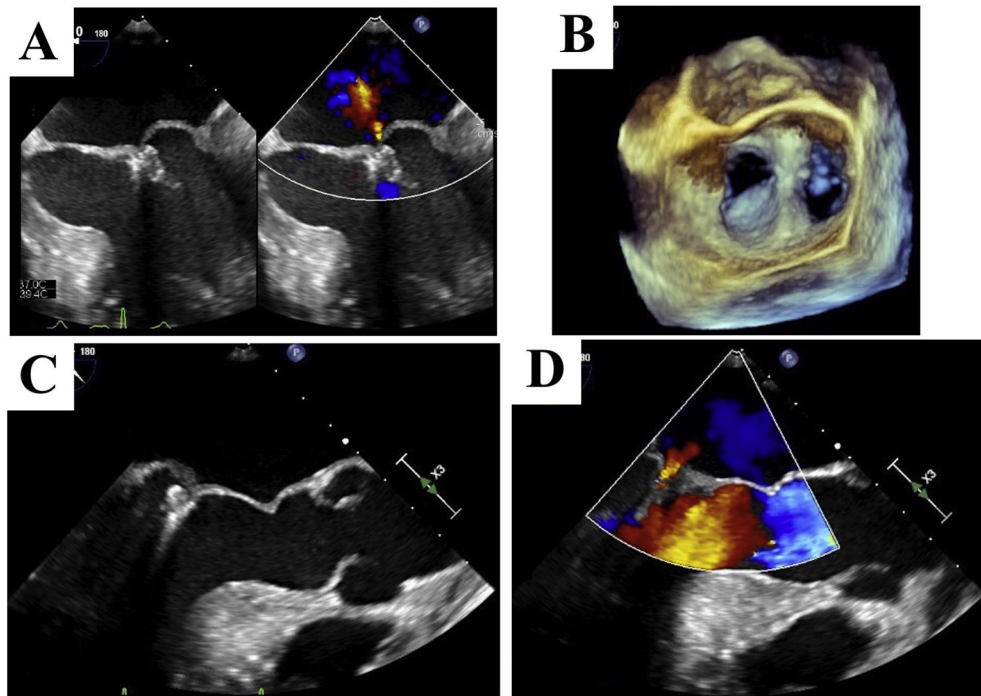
Post-MitraClip TEE. Midesophageal four-chamber view at 0° (A), three-dimensional surgeon's view (B), and midesophageal long-axis view and color Doppler at 135° (C, D) demonstrating resolution of SAM and MR with a single clip in the A2-P2 position.
